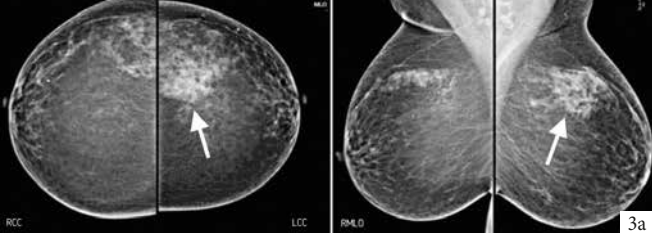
a. Focal asymmetry (arrow) appears as a denser area in less than one quadrant with no clear convex borders; this asymmetry was confirmed to be normal glandular tissue on ultrasound. b. Global asymmetry with the right breast containing more fibroglandular tissue than the left over an area larger than one quadrant; this is frequently a normal variant. c. Small asymmetry (arrow) noted in an 80 year old woman that shows growth and change in shape when reviewed 6 months later.
